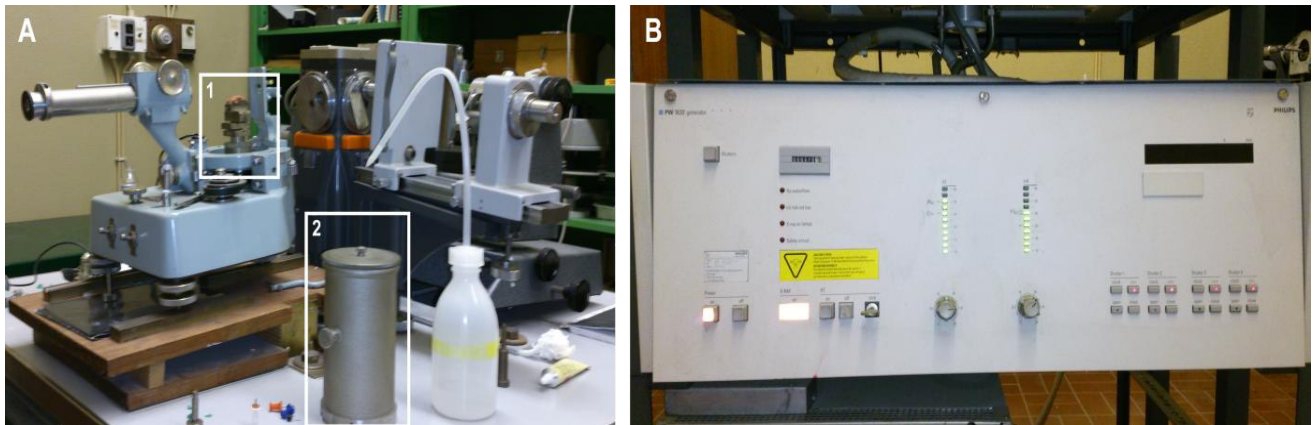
(A) Structure improvised to irradiate the cells using the X-ray generator. The tube containing the pellet of 4T1 cells was glued to the head of a tack, which in turn was attached to a piece of plasticine (placed as seen in A.1) to ensure that the cells had enough height to be in the path of the X-ray irradiation, and then covered with piece A.2. (B) The X-ray generator working at the conditions used for the irradiation.
